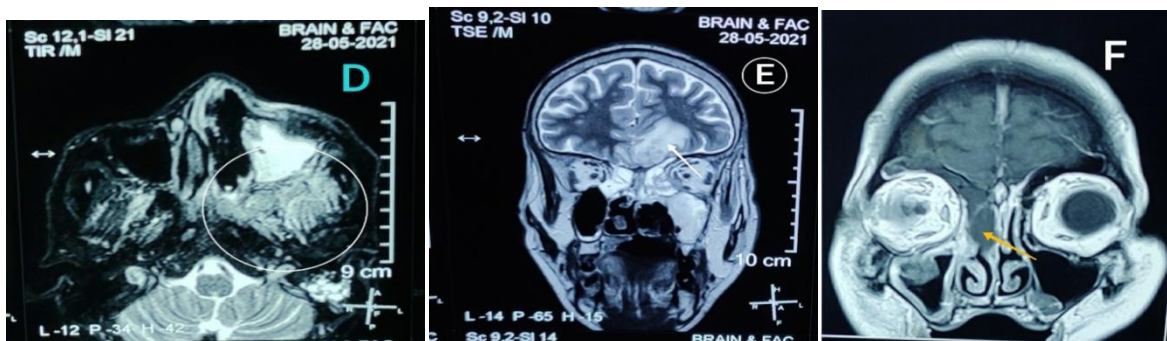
Fig D shows T2W contrast MRI of Paranasal sinuses with soft tissue infiltration and fat stranding in left pterygopalatine fossa and infratemporal fossa
